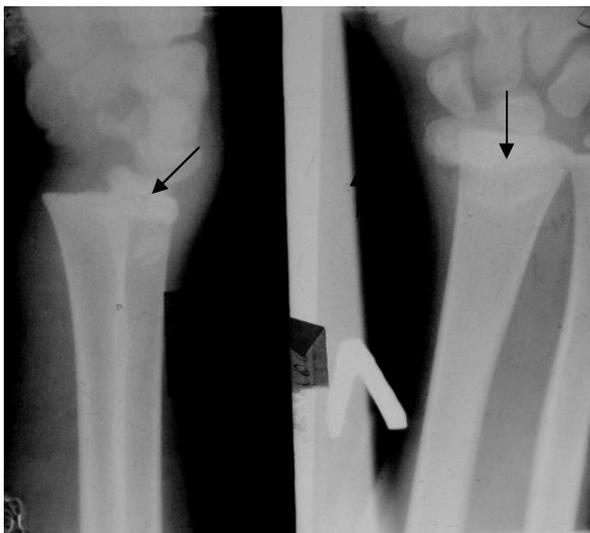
The radiograph of the left radiocarpal articulation in direct and lateral projections of a 14-year-old child. In direct and lateral projections there is a displacement of radial bone ectad and entad (arrows). Traumatic epiphysiolysis with radial bone distal epiphysis displacement.
